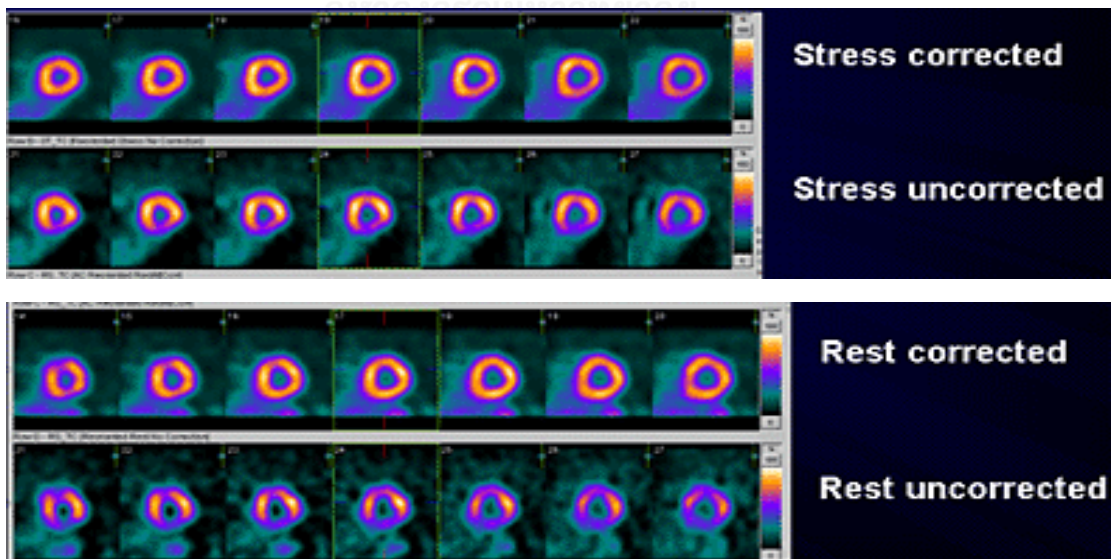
Short axial images of CT-based attenuation correction and without attenuation correction in the same patient
